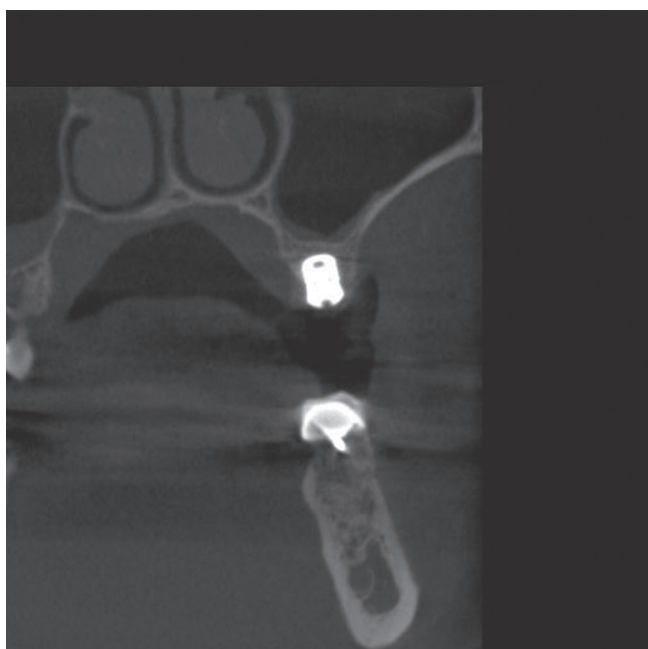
CBCT scan made 4 months after implant insertion.
